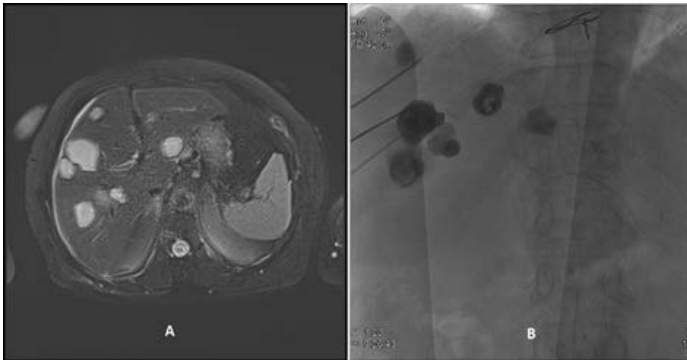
Section A represents disseminated hydatid cysts with diameters less than 6 cm are observed in the right and left lobes of the liver on T2-weighted MR sections in the axial plan. Section B represents fluoroscopic images of disseminated hydatid cysts treated percutaneously with PAIR technique.
